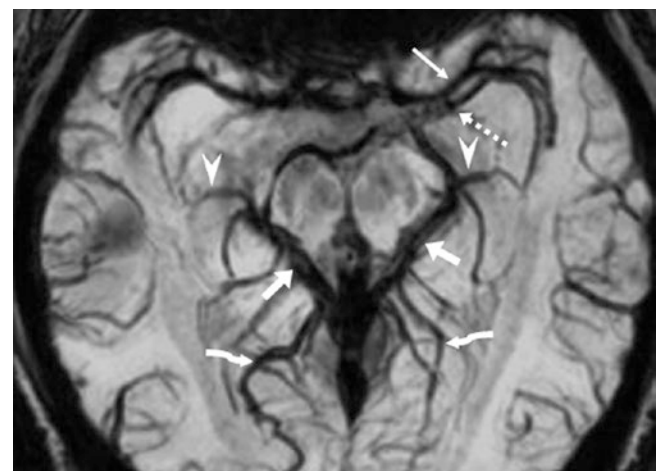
In this 33-year-old with a 3 T MRI, 16 mm thickness SWI shows the BVRs (*short arrows*), IVVs (*arrowheads*), and prominence of both the right IOV (*curved arrows*) and left deep MCV (*dotted arrow*), which is closely apposed to the MCA (*thin arrow*). The arteries are dark owing to technique
